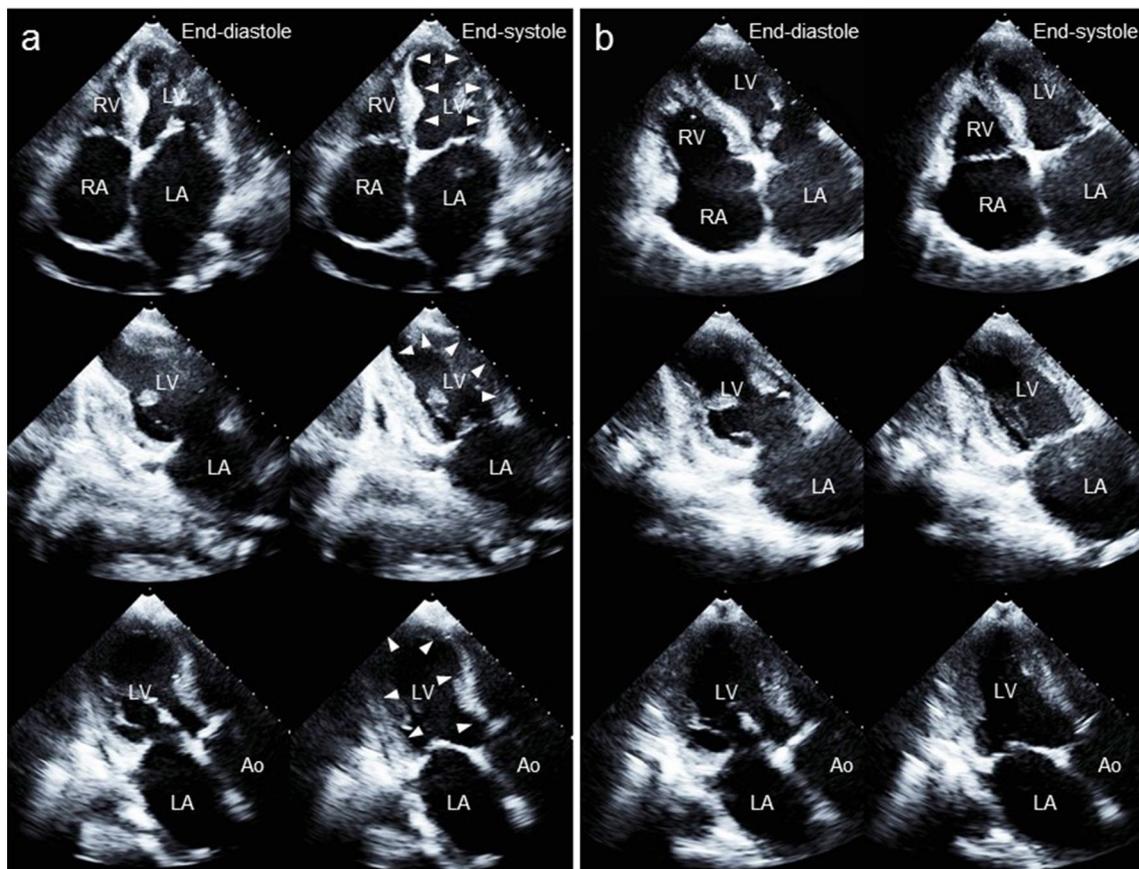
Echocardiographic change [apical four-chamber view (top), apical two-chamber view (middle), and apical three-chamber view (bottom)] of the presented case a on admission and b 14 days after admission. a Diffuse hypo-kinesis (arrow head) except for the apical
